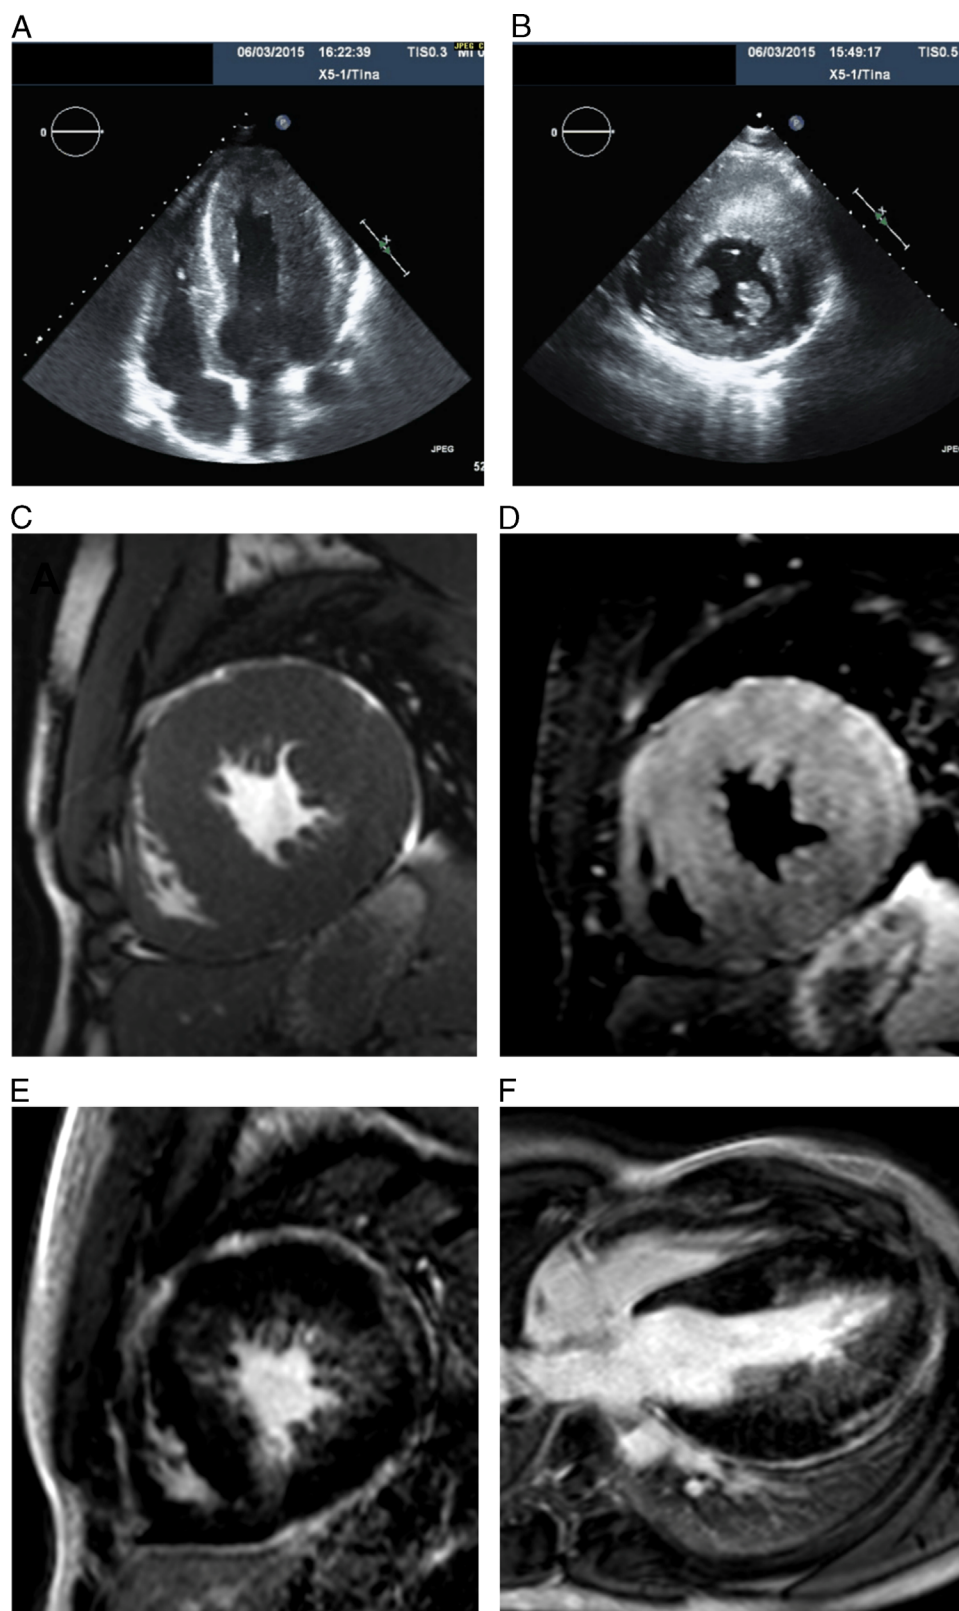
Echocardiographic imaging. A: Apical 4-chamber view and B: parasternal short axis view of the index case showing diffuse myocardial hypertrophy. Cardiac magnetic resonance imaging. C: Severe concentric left ventricular wall thickening in a representative midventricular short-axis cine-slice in end-diastole. D: Increased myocardial signal in the basal anteroseptal, anterolateral, and lateral walls on T2-weighted imaging. E, F: Late gadolinium enhancement images in short axis (E) and 4-chamber (F) orientation showed a patchy pattern of enhancement in the mid-distal anteroseptal, inferoseptal, and lateral walls.
